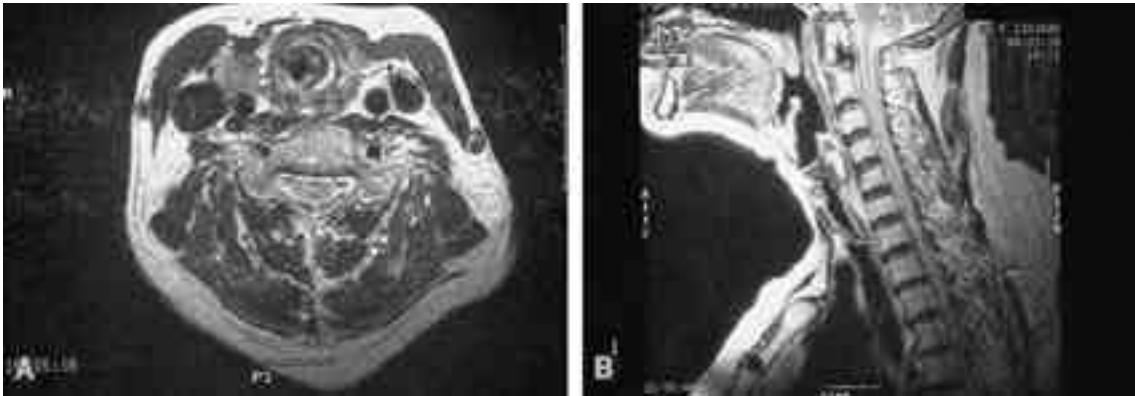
Magnetic resonance imaging of the neck. (A) An axial image reveals marked nodular narrowing(closed arrow) of upper trachea. (B) A sagittal image reveals two foci of subglottic stenosis (closed arrows).
